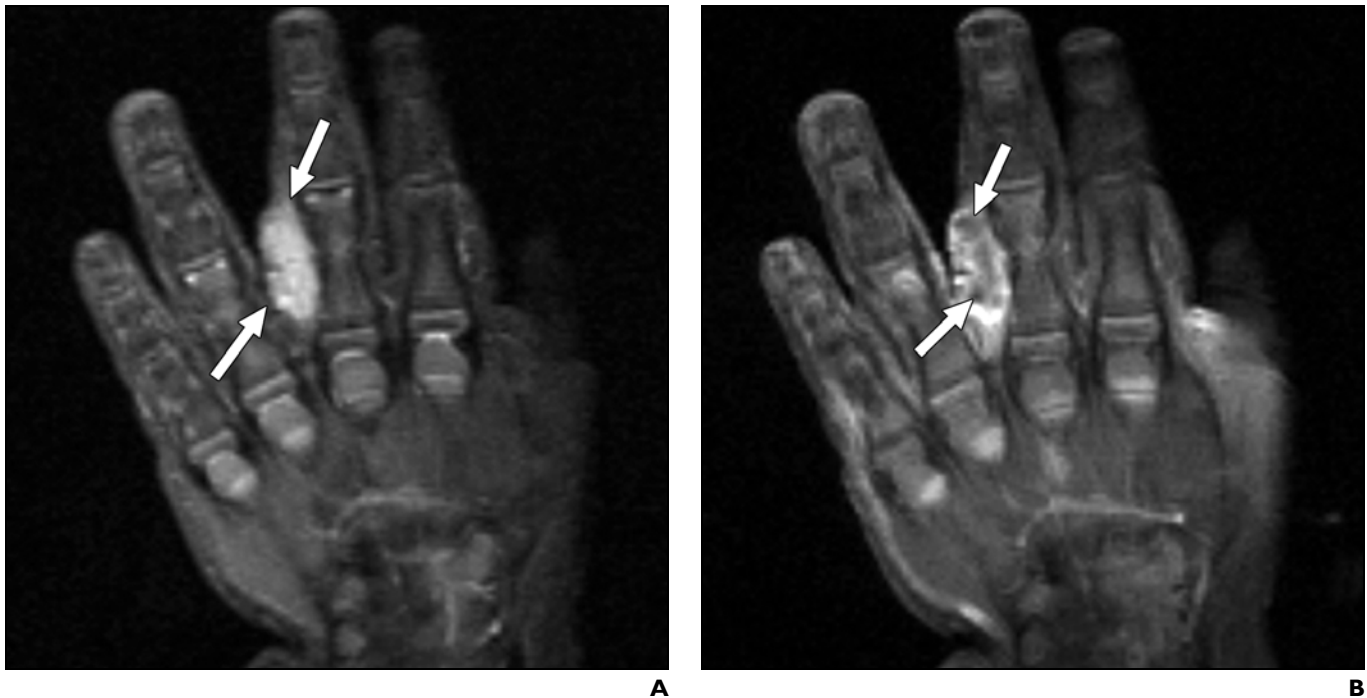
10-month-old girl with desmoid tumor of middle finger. A, T2-weighted coronal image (TR/TE, 3,000/30) shows predominantly hyperintense mass (arrows) with fairly sharp margins, except for proximal and distal margins. B, T1 contrast-enhanced coronal image (400/20) shows peripheral tumor enhancement and central lack of enhancement (arrows). Although small, this tumor necessitated amputation of digit for local control.
